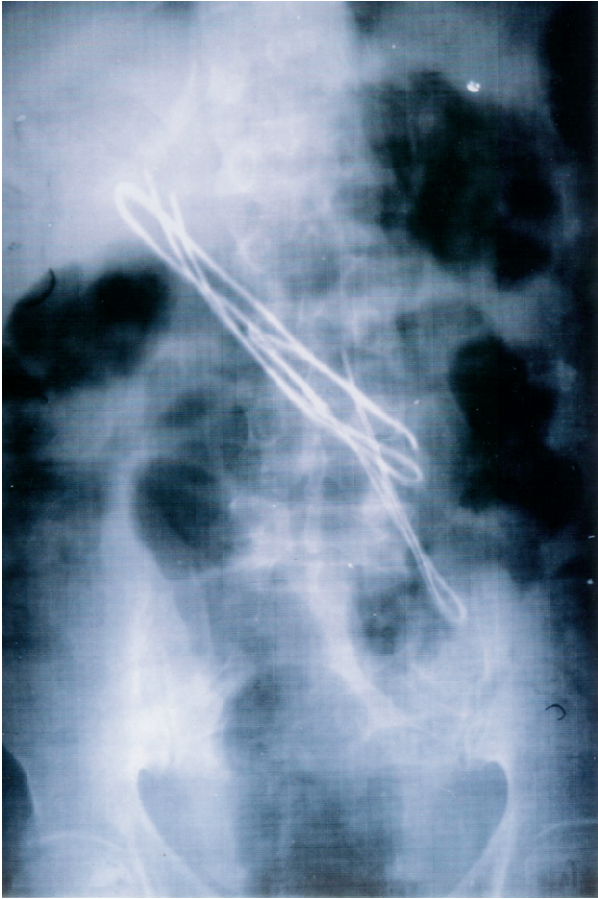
Radiograph of the abdomen showing opaque wire-like structures in the upper abdomen.
